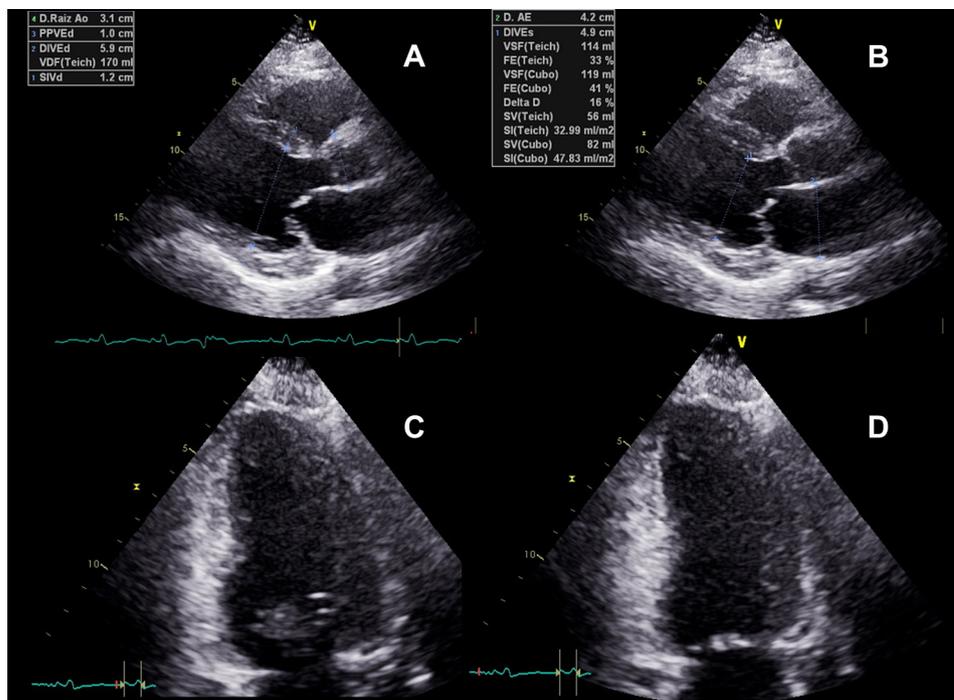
Images in transthoracic echocardiography in patient with cardiac sarcoidosis. There is increased refringency and akinesia of the basal segment of the interior lateral wall in the longitudinal parasternal view (A, diastole; and B, systole). The same patient presents akinesia of the basal segment of the inferior wall in apical 2 chamber view (C, diastole; and D, systole).
